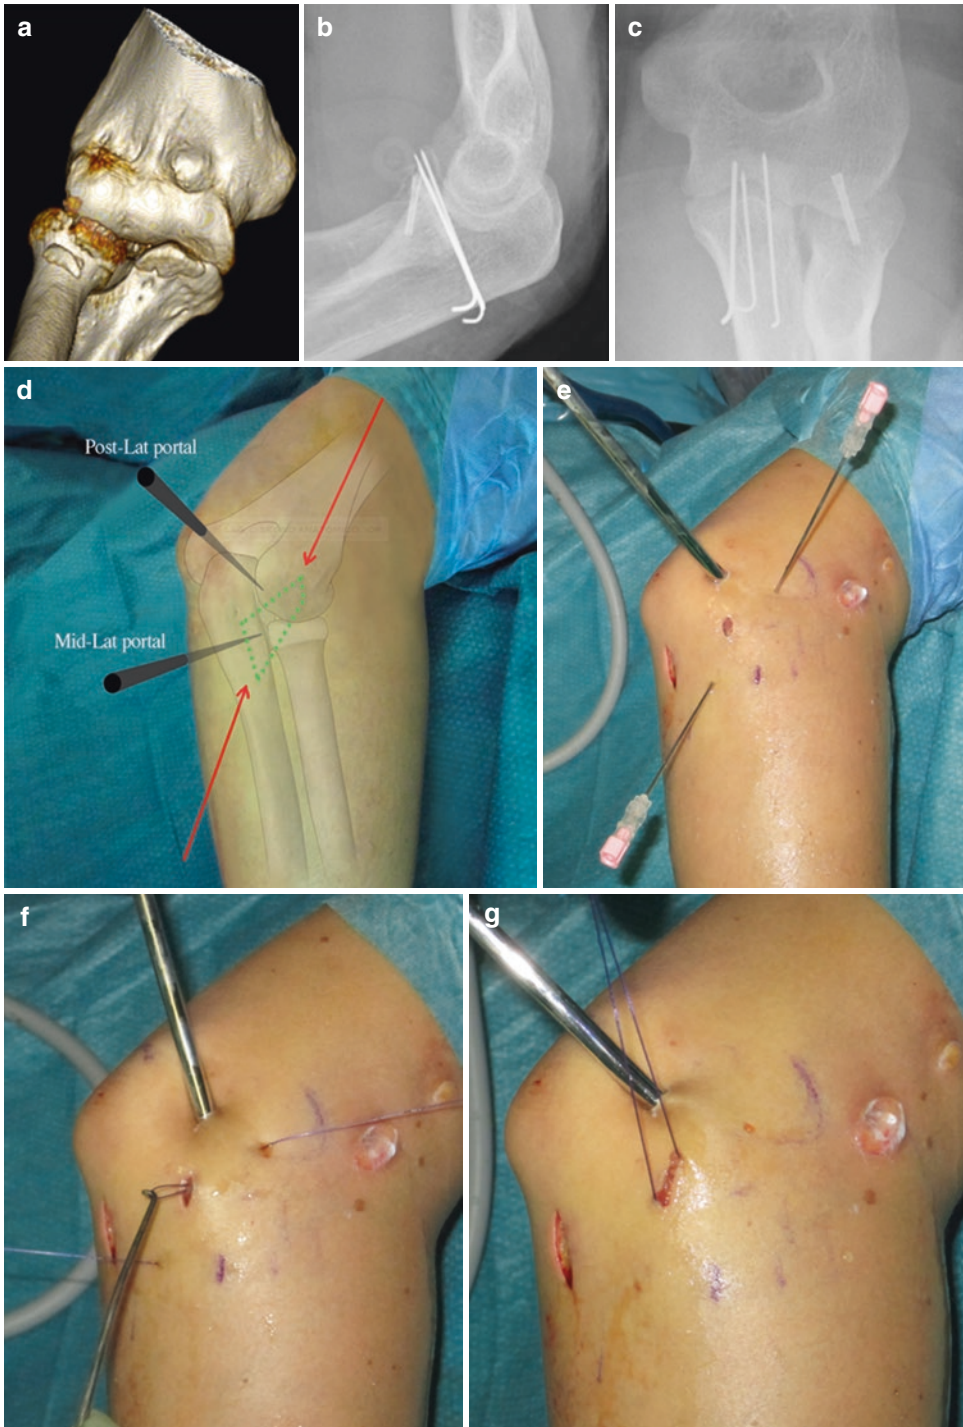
Posterolateral plication after surgical ARIF of radial head and coronoid in Terrible triad: CT scan images (a) and intraoperative X-rays (b, c) of the radial head and coronoid fracture. The scope is in through the posterolateral portal
